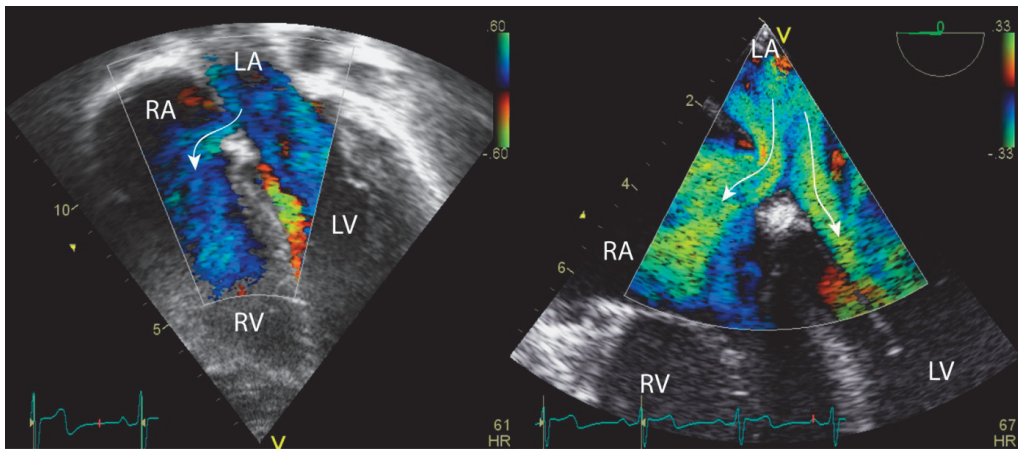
Transthoracic (left) and Transesophageal (right) four chamber views with Blood Flow Imaging; Visualization of an atrial septal defect, the left atrium (LA), left ventricle (LV), right atrium (RA) and right ventricle (RV). The arrows show the direction of the speckle pattern.
